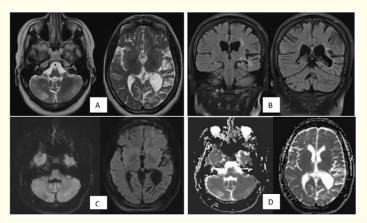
Axial T2 slices (A); coronal FLAIR (B); axial Diffusion (C) with ADC mapping (D). These images show mild vasogenic oedema in the left cerebral hemisphere, including the occipital, parietal, temporal, and insular lobes, as well as the right cerebellar hemisphere, with atrophy and dilation of the left lateral ventricle, likely due to a previous seizure.
